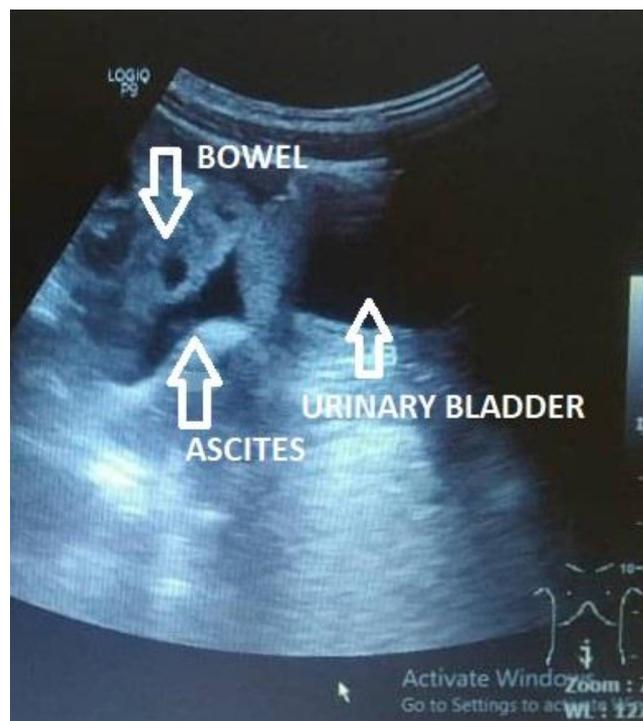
Ultrasound showed minimal ascites over the peritoneal region
